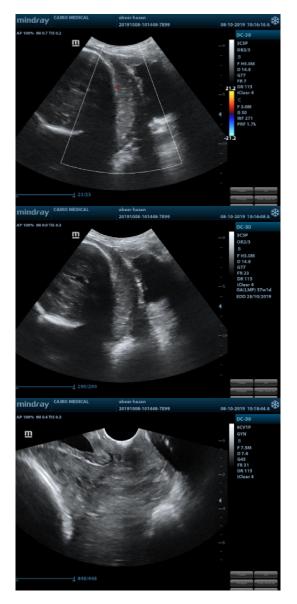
Ultrasound imaging of case 1
